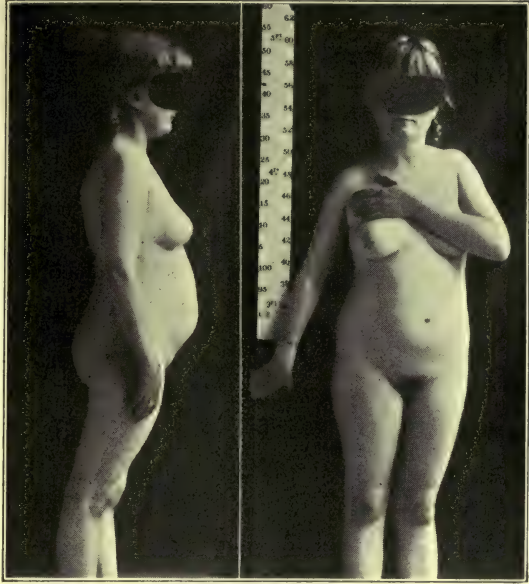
Case of Dr. Gilbert Horrax. Reproduced by author's permission from Arch. Int. Med. 1916, XVII. 629. Girl of 11 years, height 152 cm. (60 in.), (114 lbs.). At one year began to develop abnormally physically; menstruated regularly and showed other secondary characteristics just before 11 years. Supposed to be a case of pineal disease; X-Ray showed enlargement of sella turcica.
